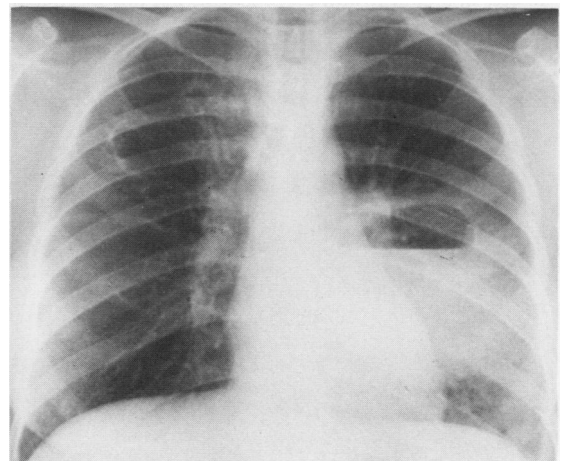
Chest radiograph showing the abscess cavity in the left lower lobe.
